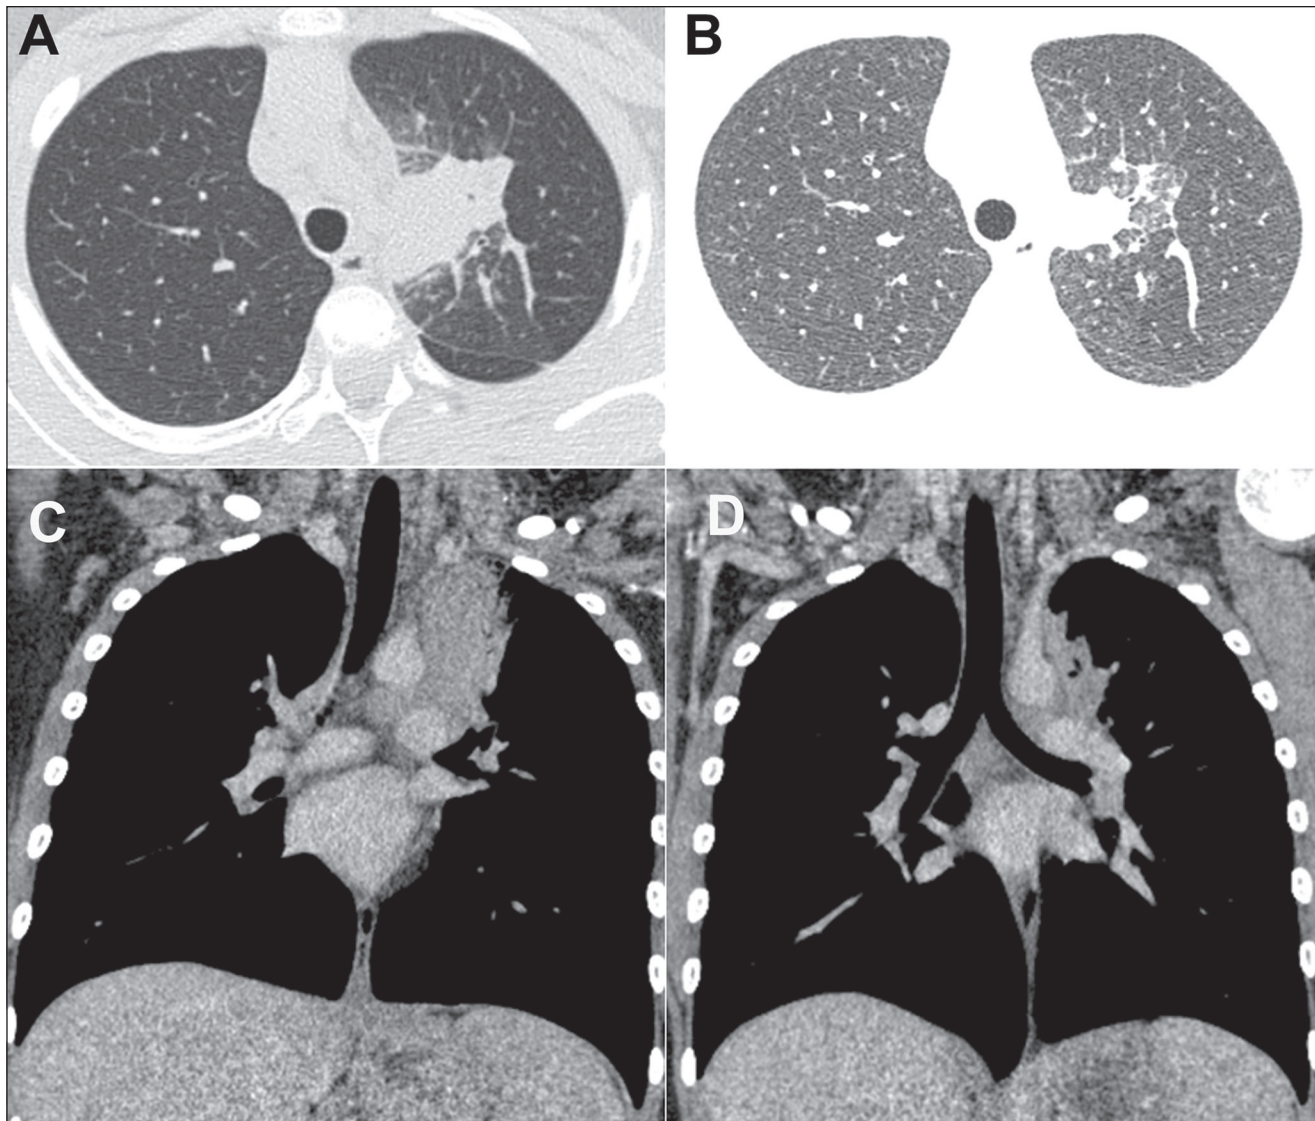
A 9-year-old girl. A,B: CT scans showing a mass in the upper left lobe, adjacent to the mediastinum, with irregular borders, initially interpreted as a neoplasm and testing positive for histoplasmosis on immunodiffusion. C,D: Control CT scans acquired one month later, showing significant regression of the lesion.
